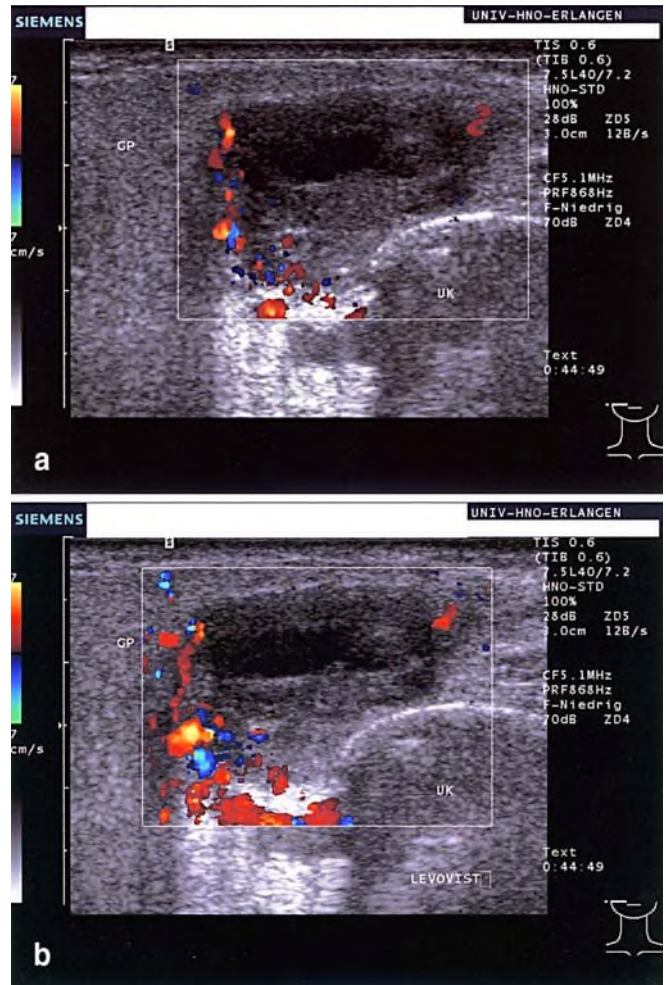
a Pre-contrast examination of an adenolymphoma. b Maximum Color Doppler signal after application of signal-enhancing agent
